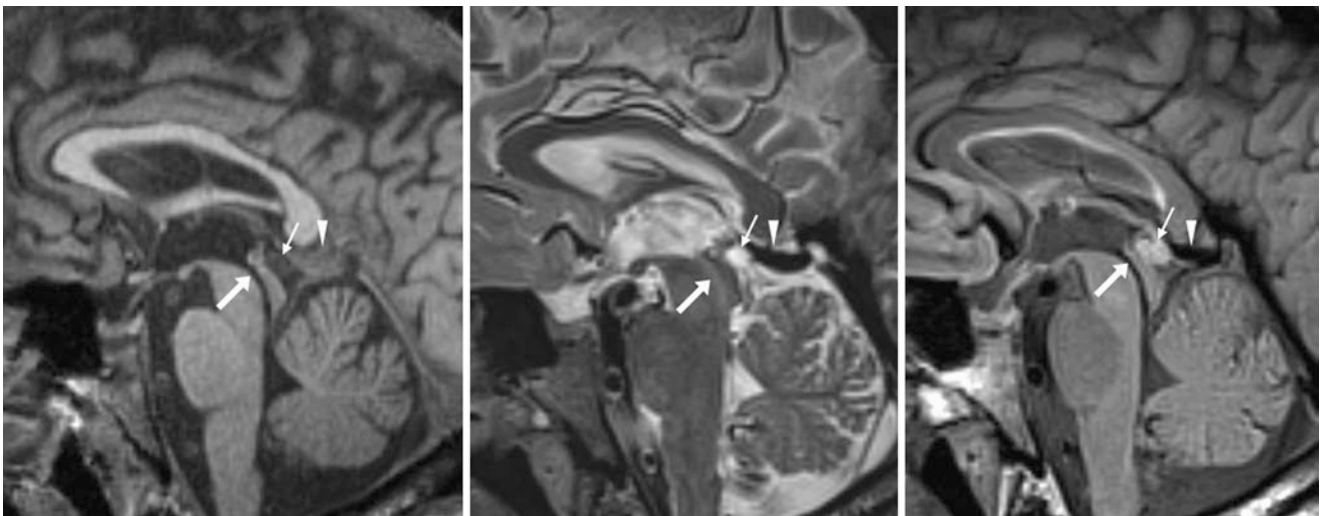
A 13-year-old who was asymptomatic but underwent a 3 T MRI as part of a research study. There is a tiny, 7-mm pineal cyst (*thin arrows*) posterior to the tectum and aqueduct (*larger arrows*; note the dark flow void indicating patency on FLAIR), as shown on sagittal 1-mm thickness T1WI (*left*), T2WI (*middle*), and FLAIR (*right*)
